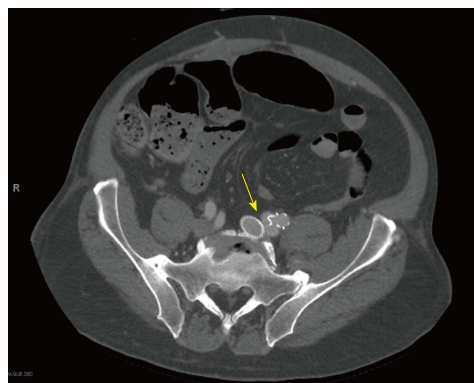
Computed tomography pelvis showing atriovenous fistula of left iliac vessels (yellow arrow) and stent in abdominal aorta.
